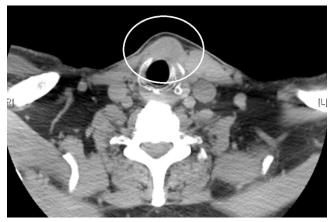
Axial CT scan of the neck. A 2.2-cm pretracheal DN involved with metastatic medullary cancer is shown anterior to the trachea, between the thyroid and cricoid cartilage.
